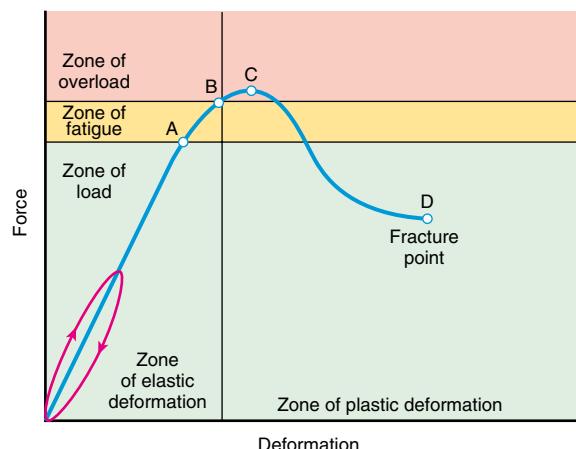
Graphic relation of bony deformation (bowing) and force (longitudinal compression) showing that the limit of an elastic response is not a fracture but plastic deformation. If the force continues, a fracture results. A, Reversible bowing with stress; B, microfractures occur; C, point of maximal strength; between C and D, bowing fractures; and D, linear fracture occurs. (Modified from Borden S IV. Roentgen recognition of acute plastic bowing of the forearm in children. Am J Roentgen Radium Ther Nucl Med. 1975;125:524–530.)
